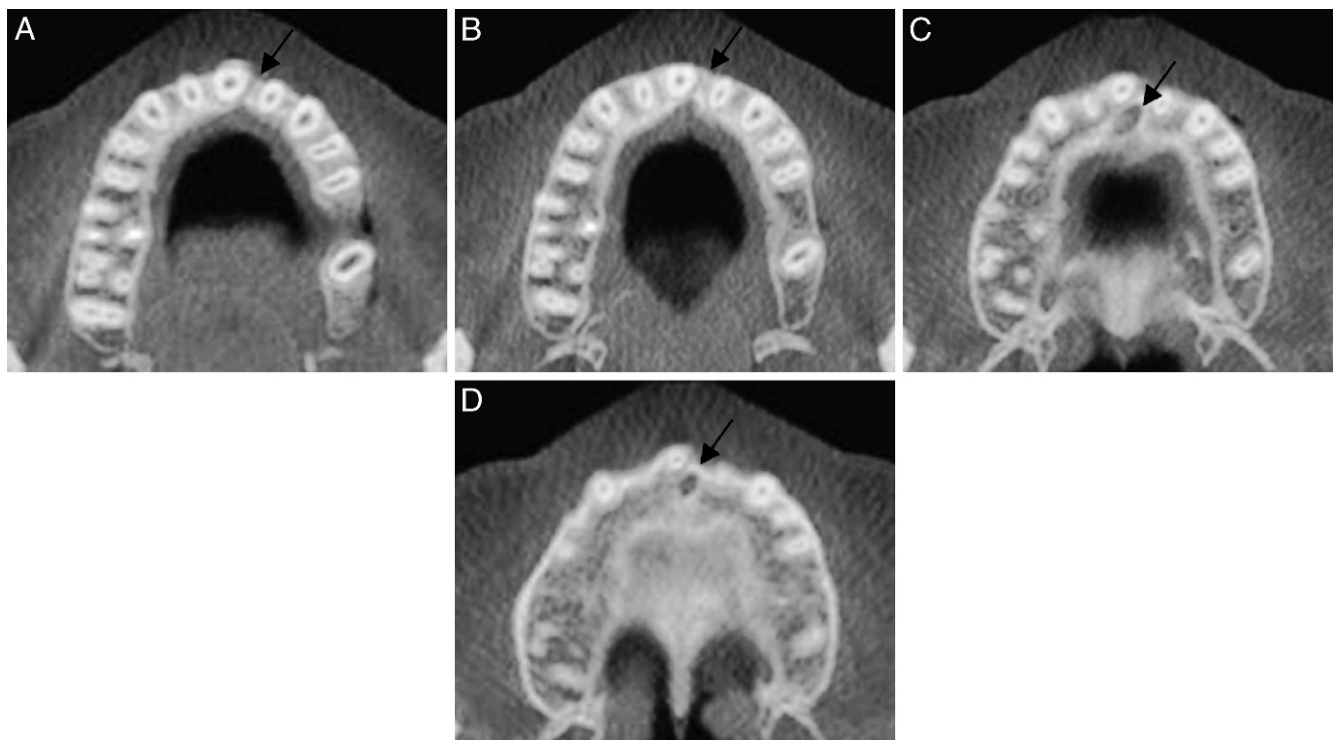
CBCT axial slices of the maxilla 5 years posttreatment. Observe the midline deviation to the left. The incisive canal also showed distortion to the left.
